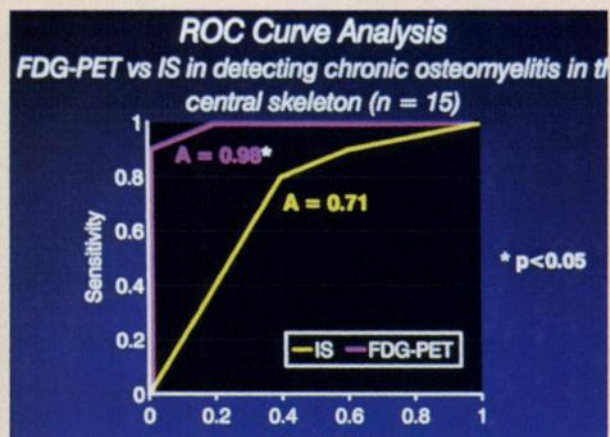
Better performance of ^{18}F -FDG compared to antibody detection of osteomyelitis (Abstract no. 122).
